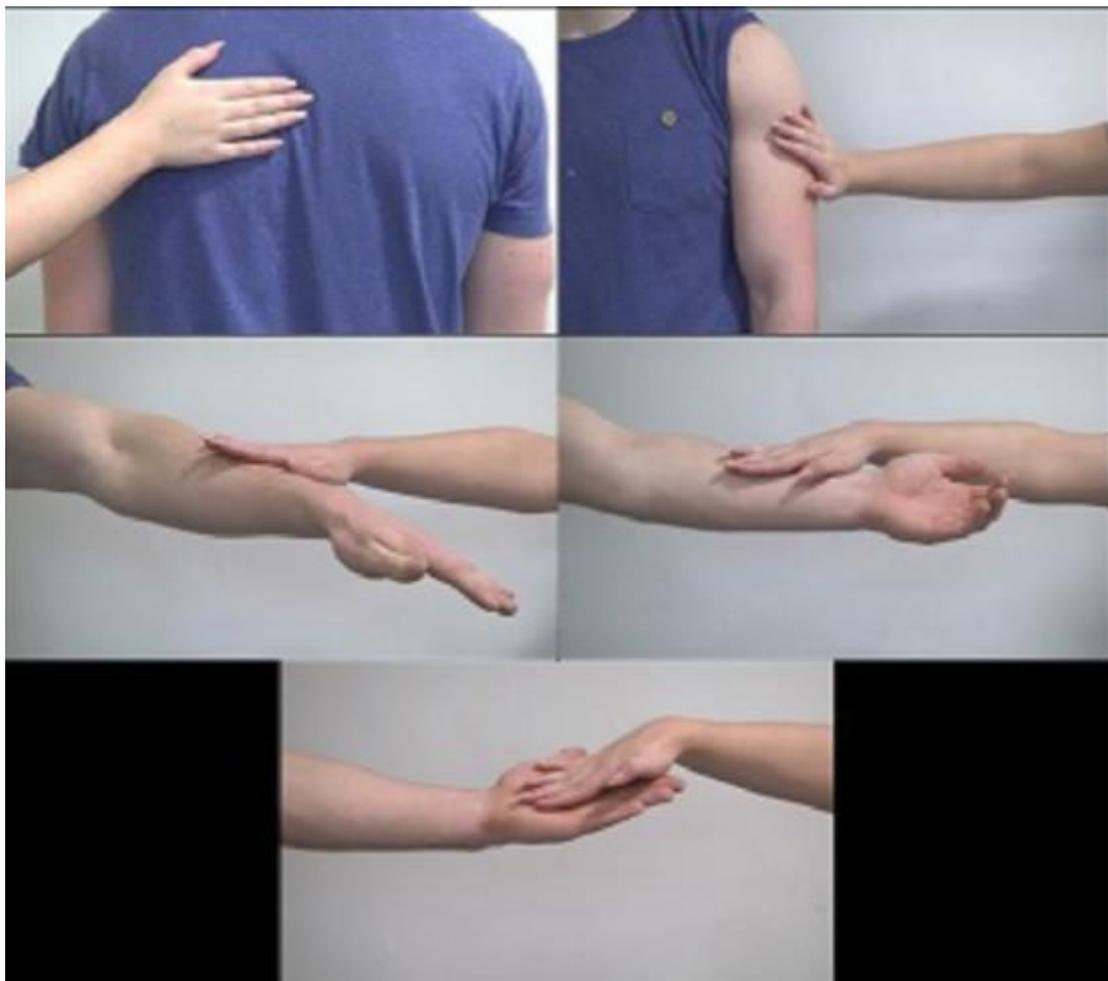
Screen shots depicting stills of each body location being stroked. Only the location being touched and the toucher’s arm are shown in these videos (from Walker et al 2017). These videos depicted touch at five locations: palm, ventral surface of the lower arm, dorsal surface of the lower arm, upper arm and back. At each of these locations, touch was delivered at three velocities: static, 3cm/s (optimal for CT stimulation) and 30cm/s (non-optimal for CT stimulation).
